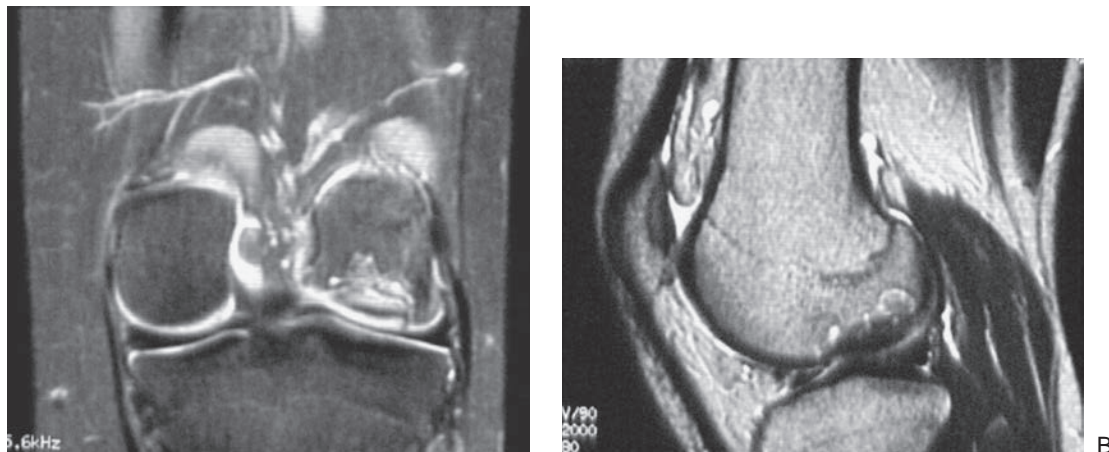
Coronal (A) and sagittal (B) T2 images from a magnetic resonance imaging scan demonstrating corticosteroid-induced avascular necrosis of the right medial femoral condyle in a 15-year-old white girl. (Courtesy of Dr. Leonard A. Mattano, Michigan State University, Kalamazoo Center for Medical Studies.)
